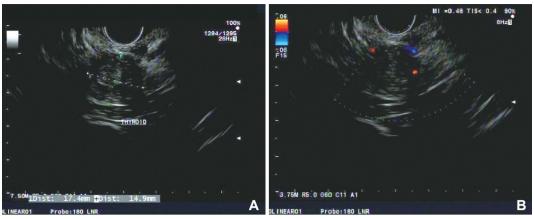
Endosonographic image of the hypoechoic mass in the right thyroid lobe (A) without and (B) with Doppler.
